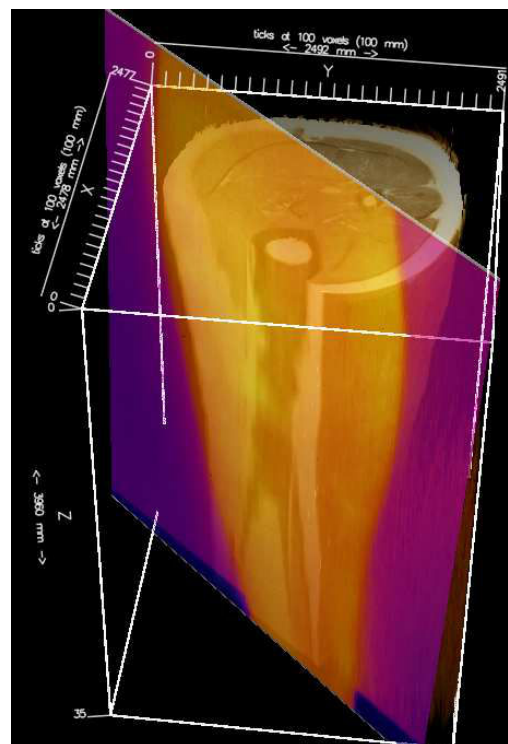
Validation of TIRI aberration due to tibial stress injury [9] via intrasubject registration of 2D TIRI to cortico-periosteal interface in 3D MRI volume. 3D MRI model generation and TIRI registration are being performed within the AvisoFire and Drishti-2 volume exploration environments at the IVEC supercomputing facility.
